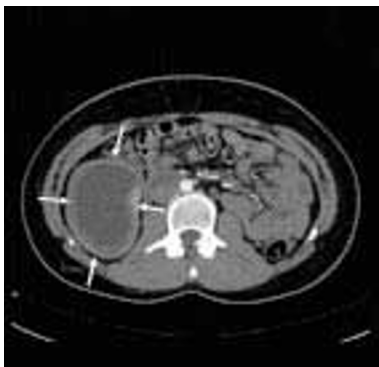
Computed tomography angiography. The arrows indicate the hydatid cyst.
